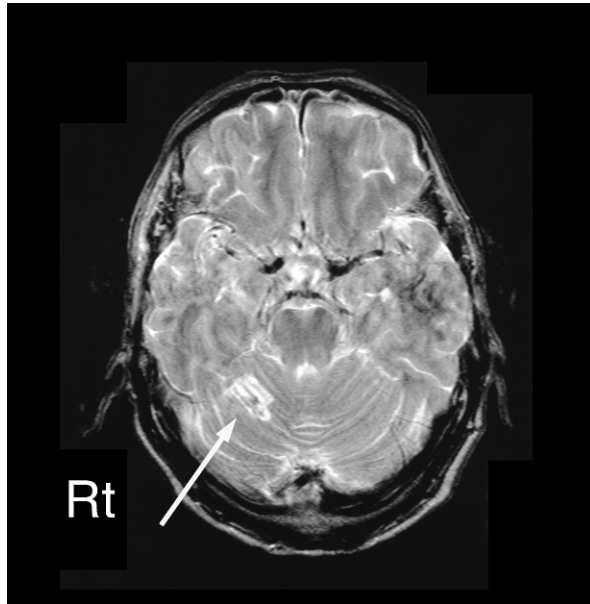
T2-weighted cranial MRI (TR 3600 msec / TE 96 msec). An infarct was located in the lobulus quadrangularis and lobulus simplex on the right side. Paravermal zone was involved in the infarct.
